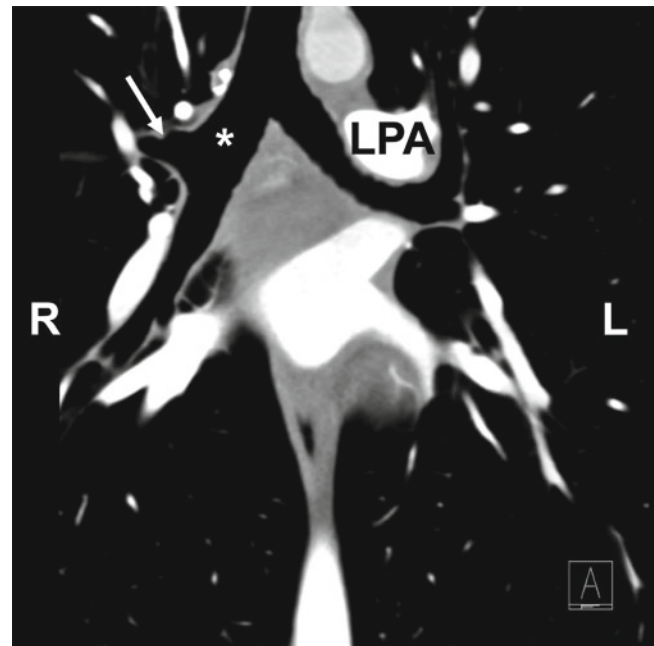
A coronal CT image demonstrating the normal central bronchial anatomy which can be used to help differentiate the morphologic right lung from the morphologic left lung. The right main stem bronchus (*asterisk*) is more vertically oriented with an early branch point (*white arrow*), *LPA* left pulmonary artery
